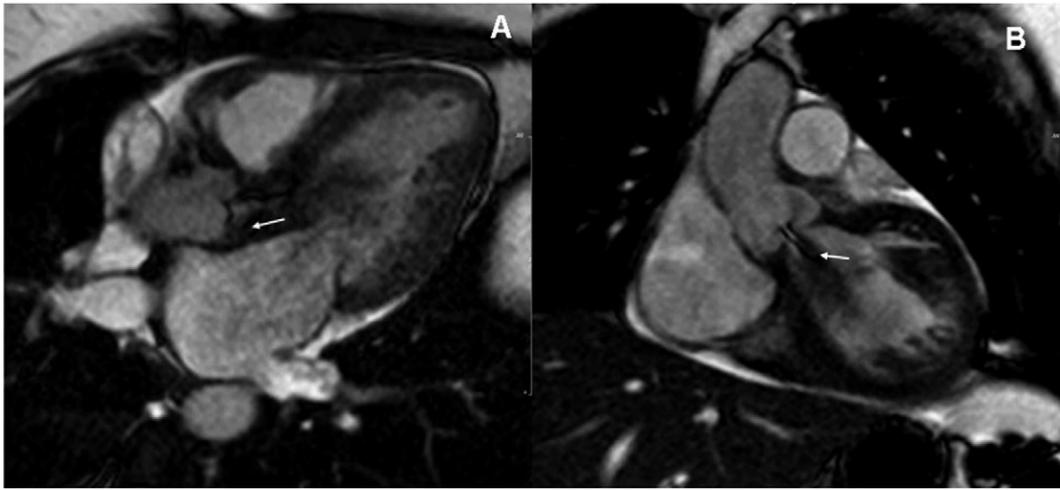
Cardiac magnetic resonance imaging confirmed the presence of severe aortic regurgitation, represented by signal dephasing (arrows; A: axial image through the left ventricular outflow tract on the steady-state free precession sequence; B: oblique image through the left ventricular outflow tract on the steady-state free precession sequence). There was no evidence of Takayasu's arteritis on cardiac magnetic resonance imaging.
